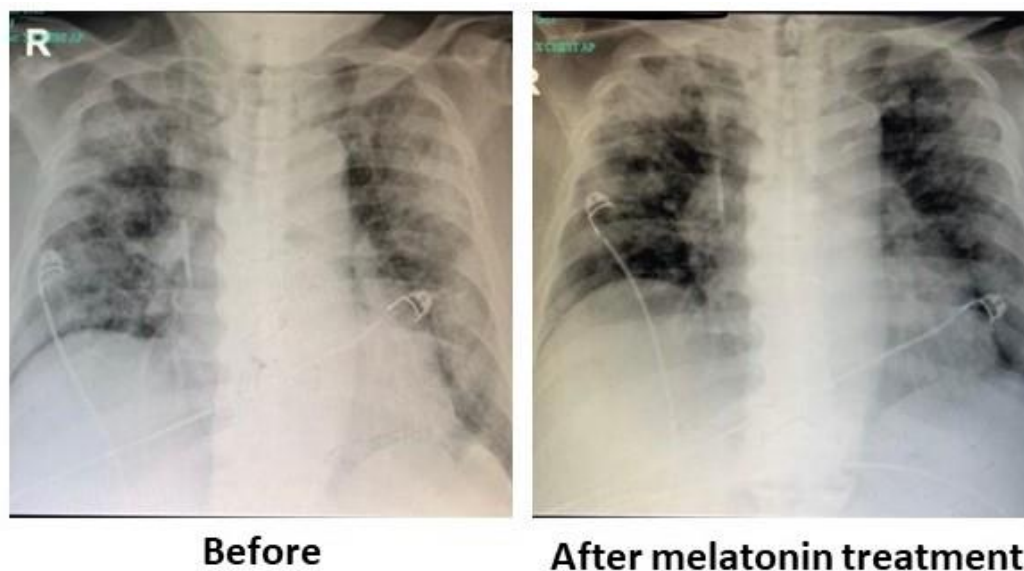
The representative x-ray graphs of a COVID19 patient before and after melatonin as an adjuvant treatment.
